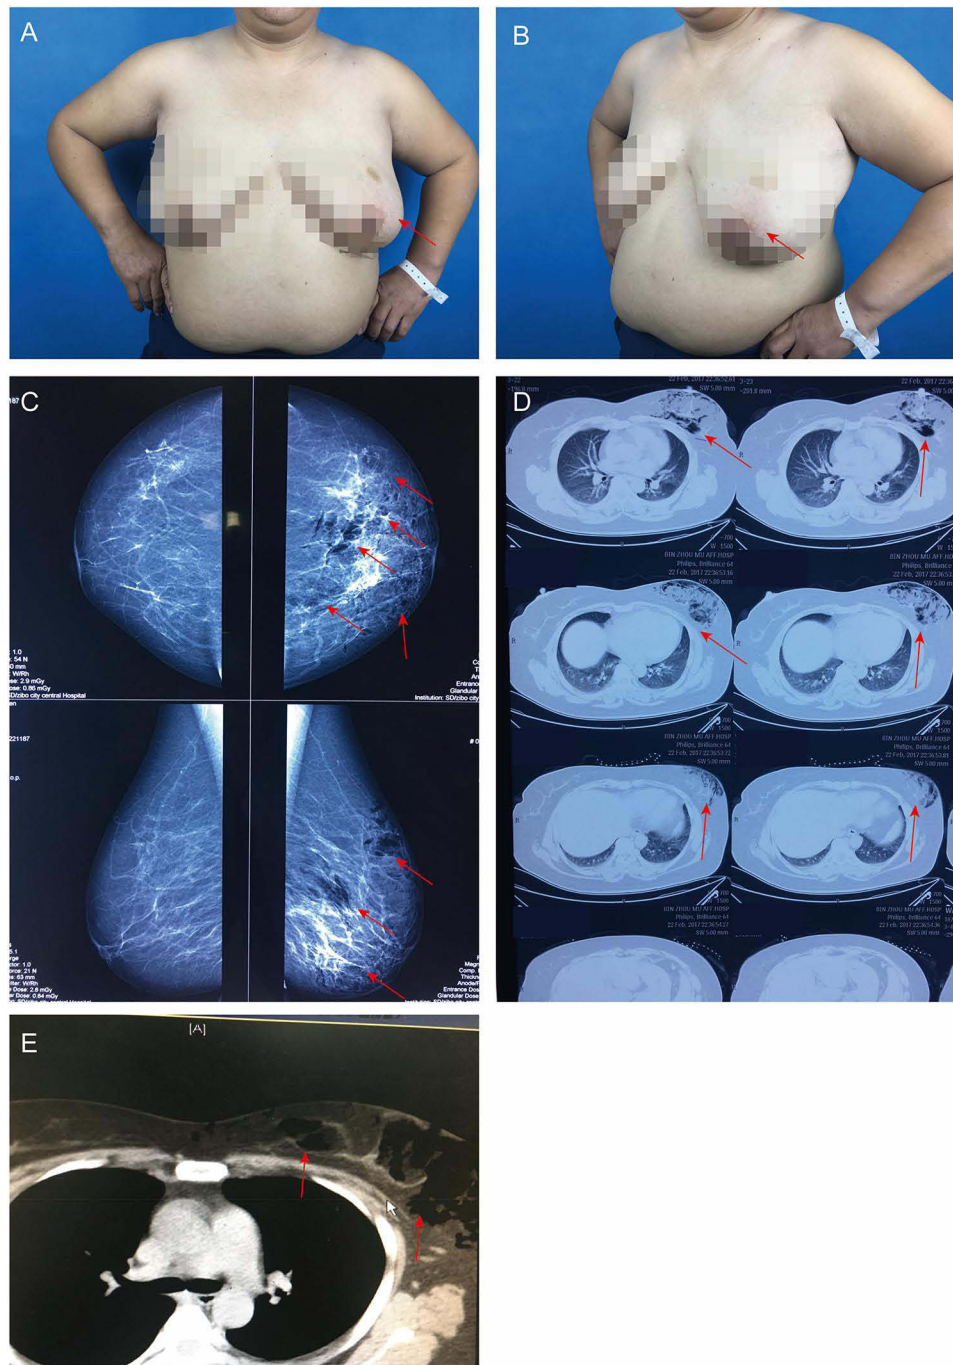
Preoperative clinical signs and imaging findings of the patient. (A and B) clinical photograph showing localized swelling and erythema of the left breast and tenderness on palpation; (C) mammographic view of the left breast demonstrating multiple radiolucent gas shadows, consistent with gas accumulation, and diffuse increased density in the mammary tissue layer, indicative of inflammatory changes; (D and E) computed tomography revealed a gas-density opacity in the left mammary region. Red arrows point to the locations of both visible lesions and radiographic anomalies.
